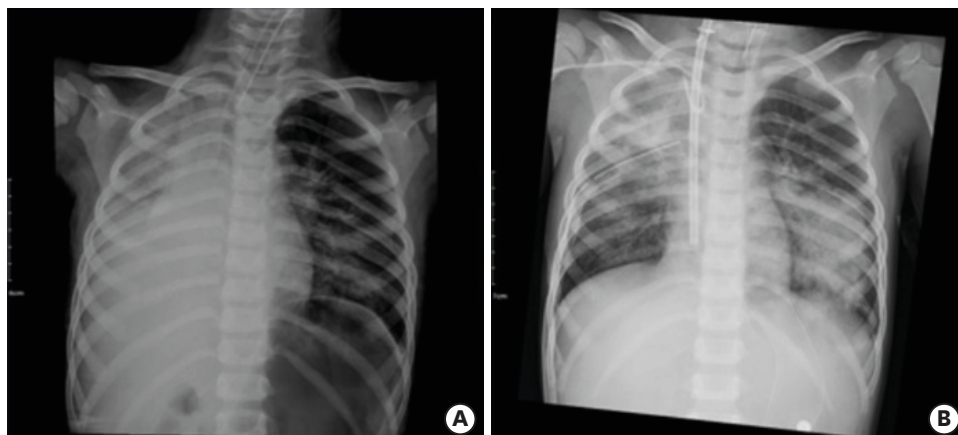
(A) Initial status of plastic bronchitis; initial chest radiograph showed that the 6-year-old patient's right lung was totally collapsed. (B) Status of plastic bronchitis after bronchoalveolar lavage; after removal of the thick mucus plugs, the right lung could be ventilated, and the tracheal deviation decreased. Infiltration of the left lower lung was present.
